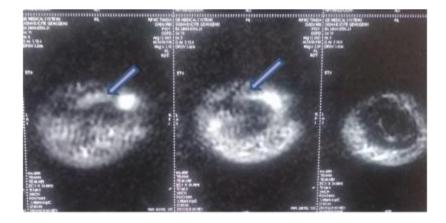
MRI showing soft tissue lesion in the dorsal aspect of distal phalanx of left thumb
